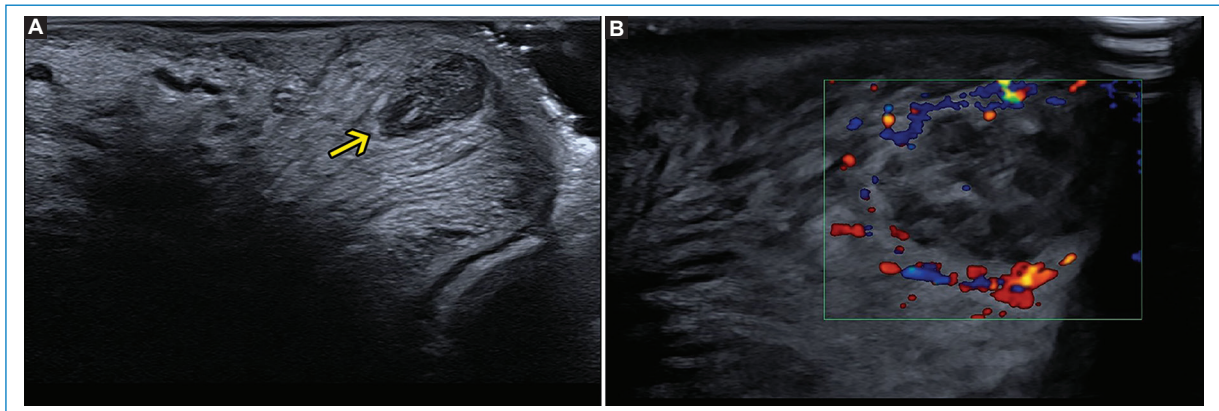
Patient who reported a localized and progressive increase in volume after having eaten fish with bones 10 days earlier. The ultrasound showed the increase in volume correlated with a collection with heterogeneous hypoechoic content (A), partially delimited, avascular and with peripheral hyperemia (B).
